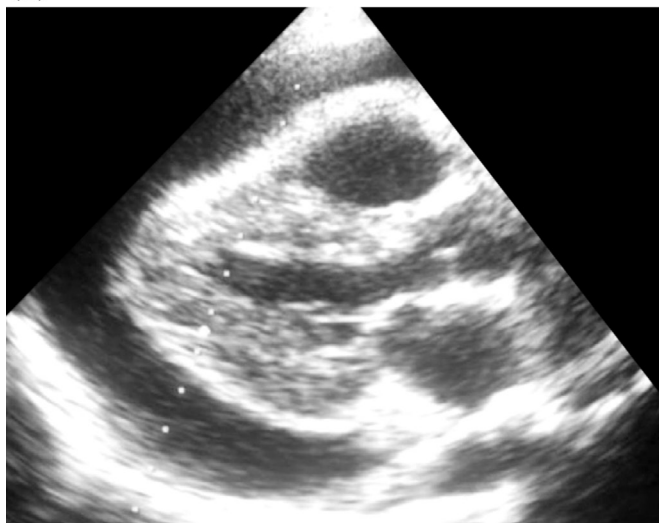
Chest X-ray in a 13-year-old boy with FMF (Panel A) and an echocardiogram study of the same patient (Panel B) demonstrating an expanded cardiac silhouette (A) and abundant pericardial fluids compressing the myocardium (B), suggestive of cardiac tamponade. Adapted from Sanchez Ferrer et al. [137].
